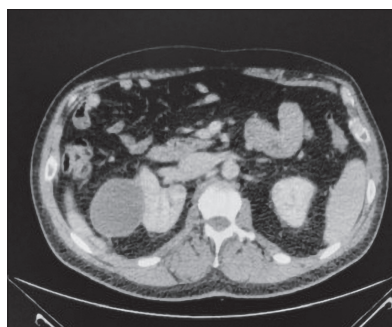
Abdominal computed tomography scan two days after the acute event
